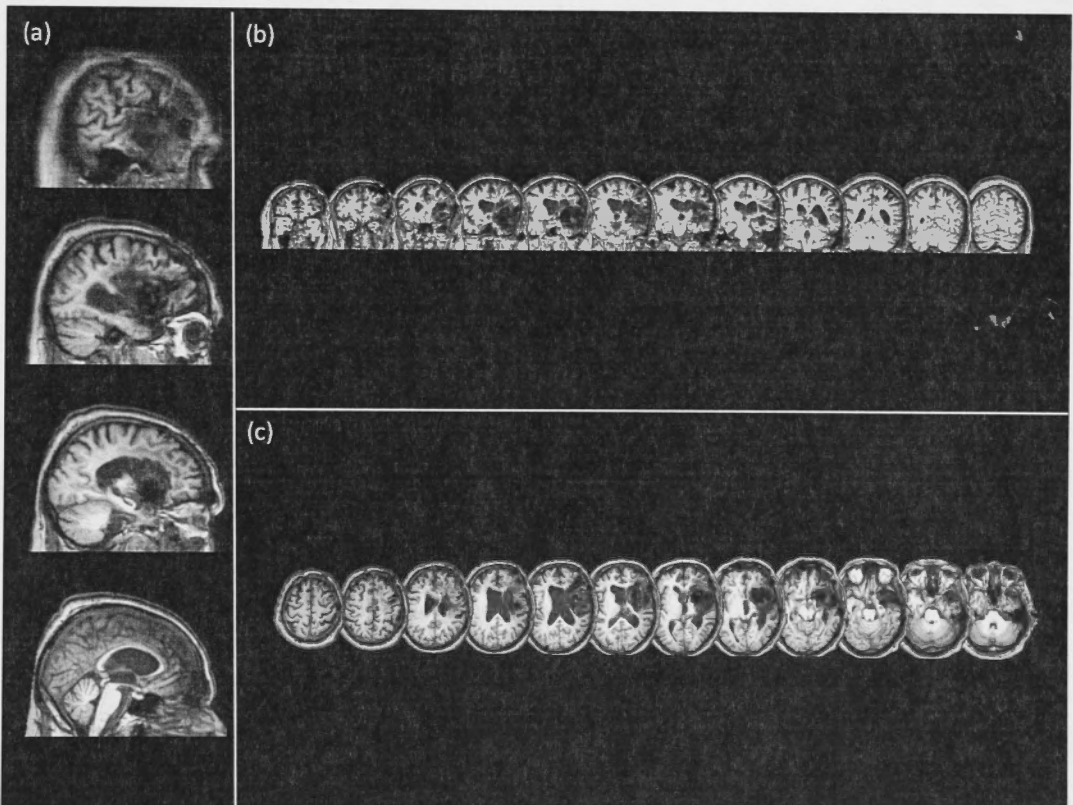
T1-weighted brain MR images of patient JF:
